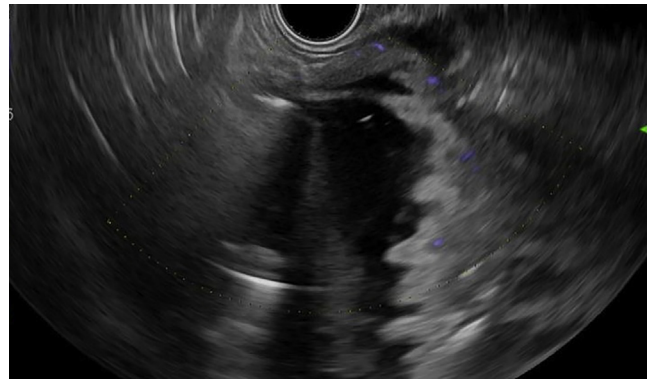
Endosonographic image showing identification of jejunal limb for creation of gastrojejunostomy.
